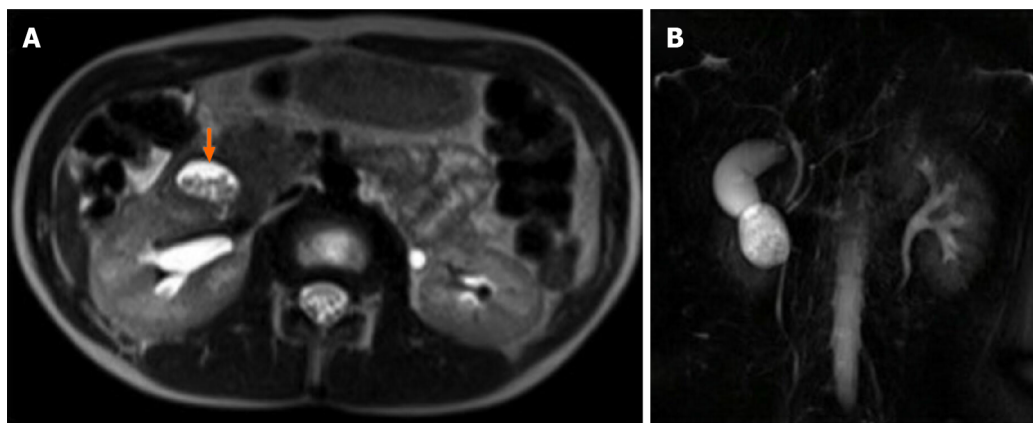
Magnetic resonance imaging. A: Oval mass is located below the gallbladder and lateral to the common bile duct and pancreatic duct, adjacent to the pancreatic head. The cyst was filled with fluid and multiple stones; B: Cholangiographic reconstruction showed normal gallbladder and intra- and extrahepatic bile ducts.
